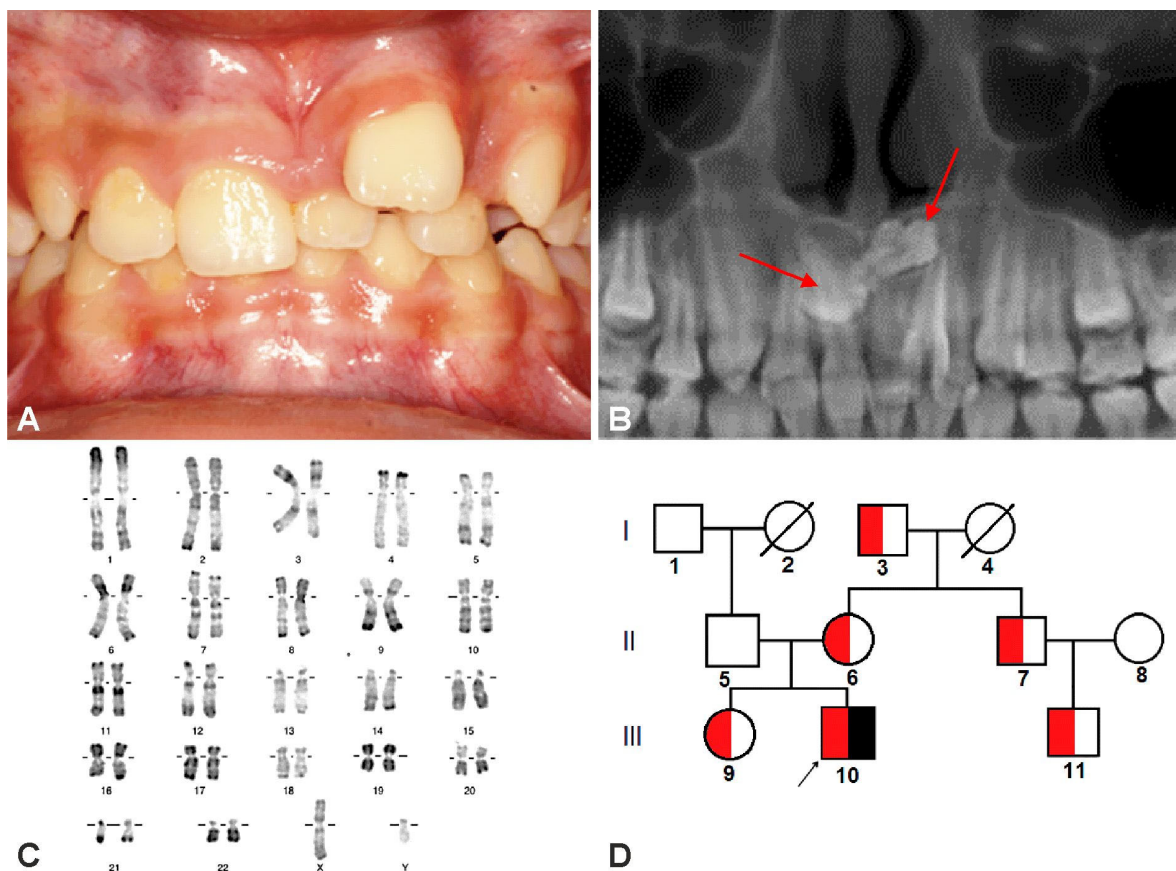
Supernumerary teeth: upper anteriors deciduous teeth (mesiodens) – isolated, sporadic, non-hereditary, nonsyndromic case associated with dental crowding, familial character, expression variability (12-year-old boy). Intraorally frontal view in occlusion reveals the clinical dental phenotype (A); panoramic radiograph: location of the two supernumerary upper anteriors (B); karyotype 46,XY: normal male (C); the family tree: isolated, sporadic case (D).
